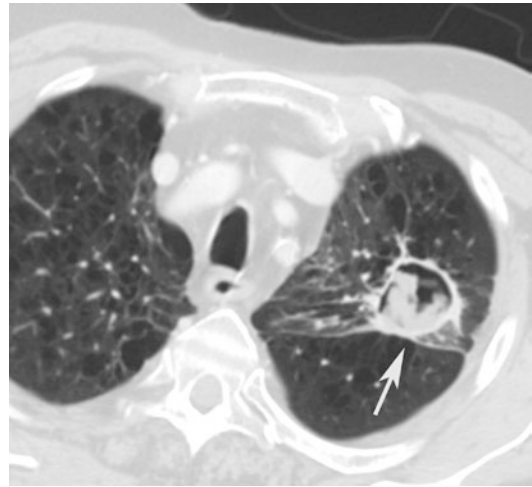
Fungal abscess (white arrow) in diffuse pulmonary emphysema. Post-contrast CT axial scan demonstrates large air-containing dishomogeneous focal area, with peripheral-enhanced irregular wall, characteristic of fungal abscess, with underlying pulmonary emphysema
